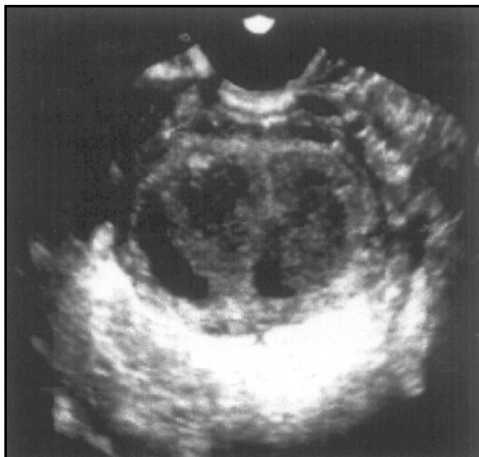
Transabdominal picture (ultrasound) showing a multiloculated ovarian cyst on right side.
